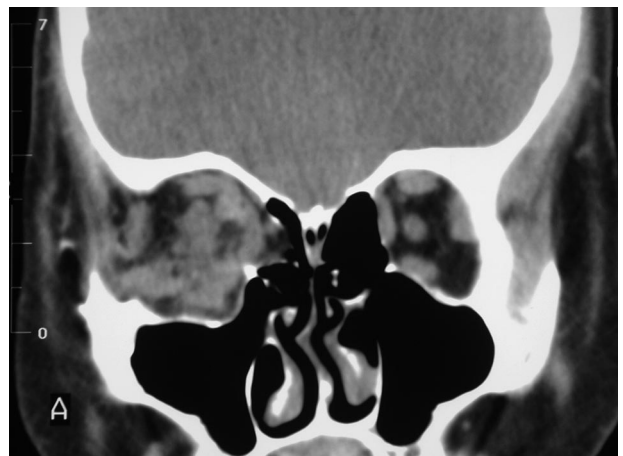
Coronal CT scan demonstrating effect of 3-wall decompression.
